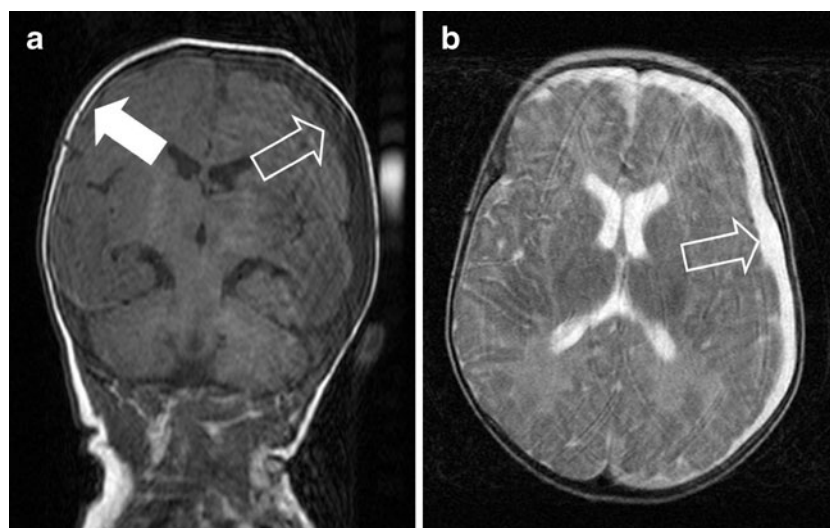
a Case 5. Coronal T1-weighted MR image of a 5-month-old boy who fell from a carry cot. *Information not available to the participating radiologists:* the boy was brought to the emergency department after a trauma with immediate clinical signs. He was pale, weak, and unresponsive and was admitted to the pediatric ward. The clinical history later changed into an abusive incident. The MR scan was performed after
